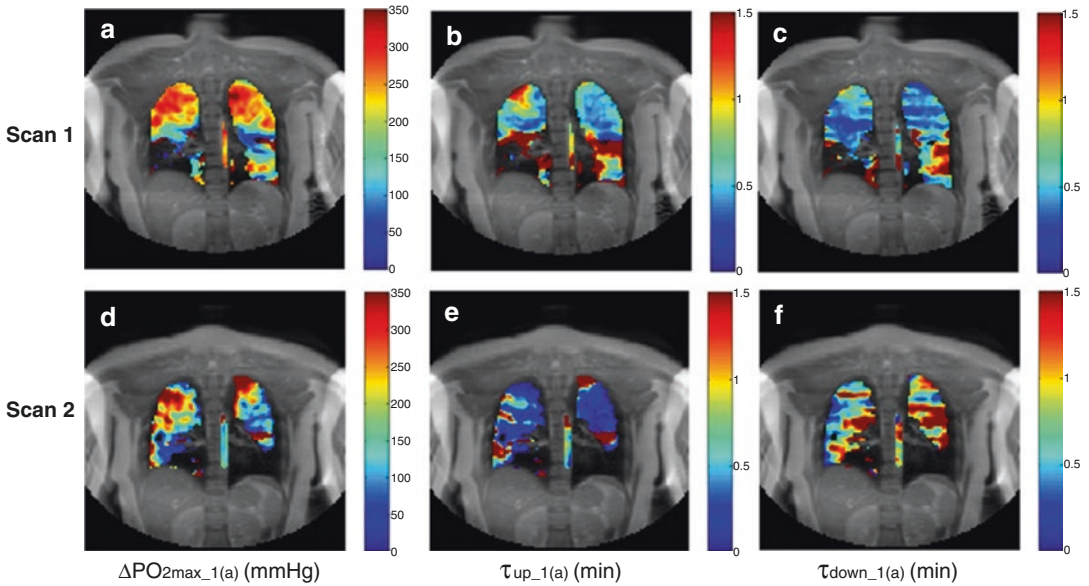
Dynamic oxygen-enhanced MRI parameter maps from a severe asthmatic participant (female, 19 years old, FEV₁% predicted = 64 %) from the scan (V1) and rescans (V2). (a–c) Maps of ΔPO_{2max} , τ_{up_1} and τ_{down_1} from the first
